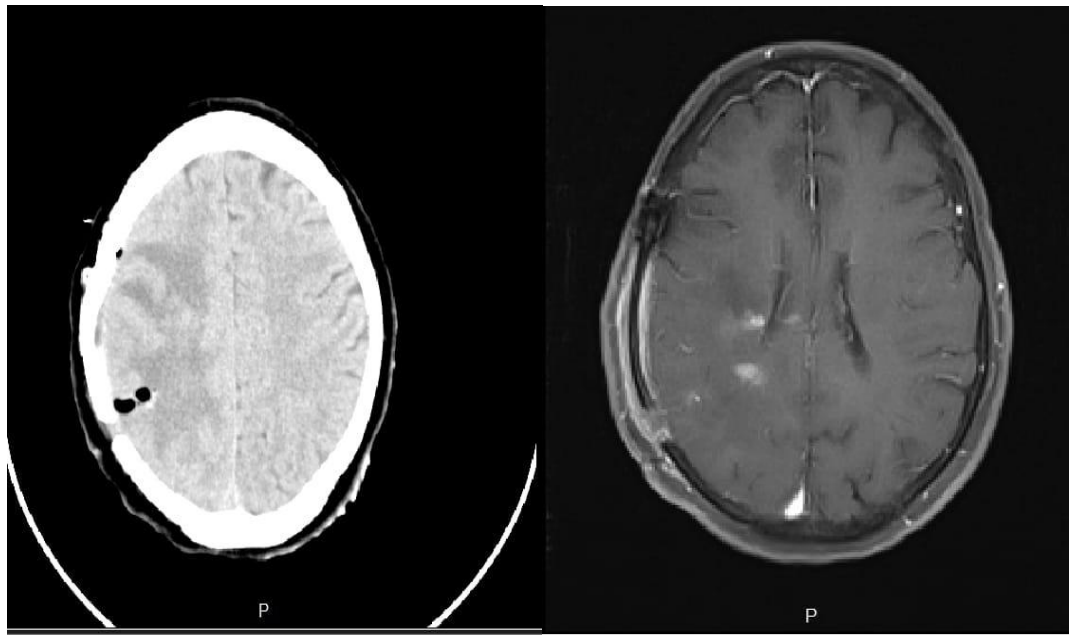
Post-operation DWI and DWII imaging (After initial administration of high-dose corticosteroids)
